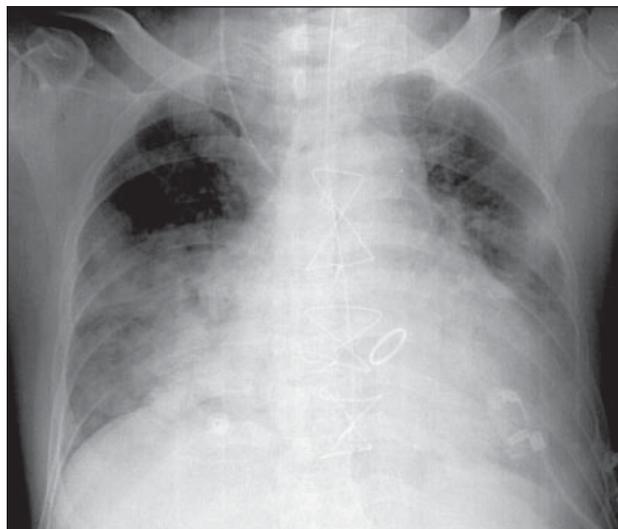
Frontal chest X-ray of a 59-year-old man with underlying valvular heart disease, now diagnosed with severe acute respiratory syndrome showing diffuse confluent areas of consolidation in both lungs.
